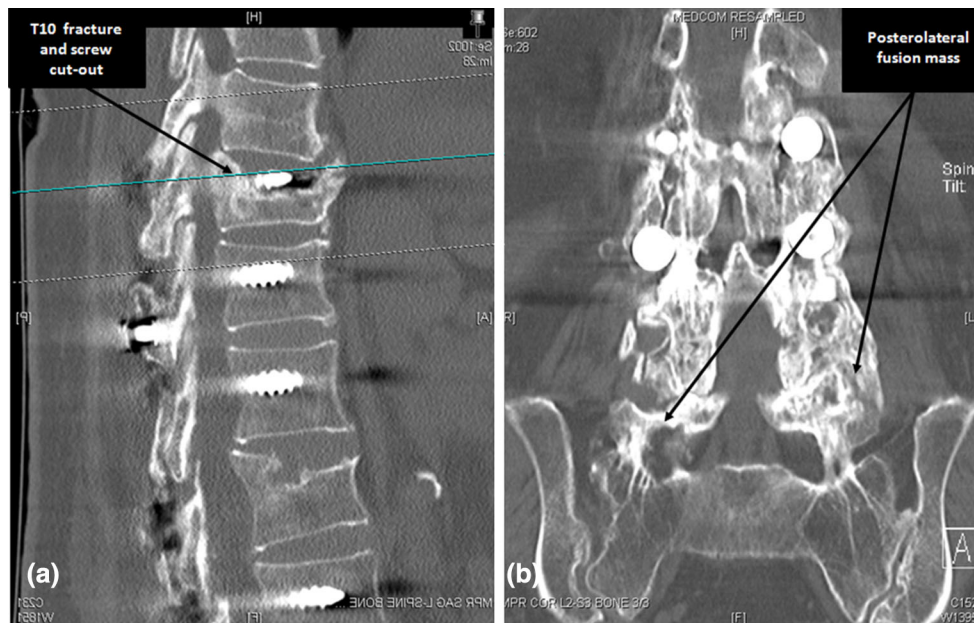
Pre-operative computed tomography (CT) scan of the spine as shown above. a T10 fracture and screw cut-out. b Posterolateral fusion mass
